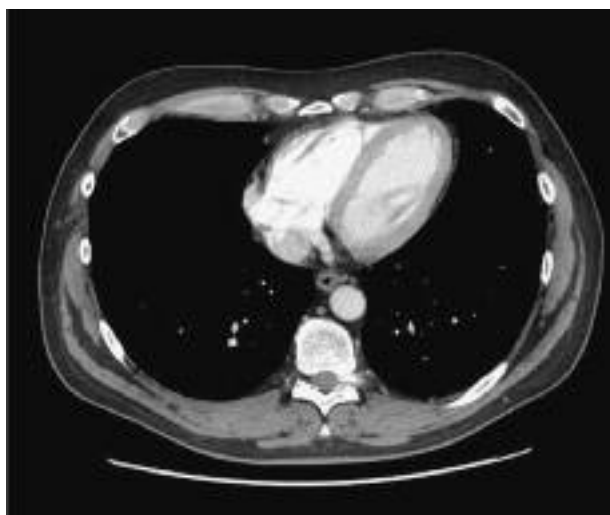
Preoperative axial CT-scan of the lower thoracic spine, showing a dense calcification in the left Th9-Th10 neuroforamen.
